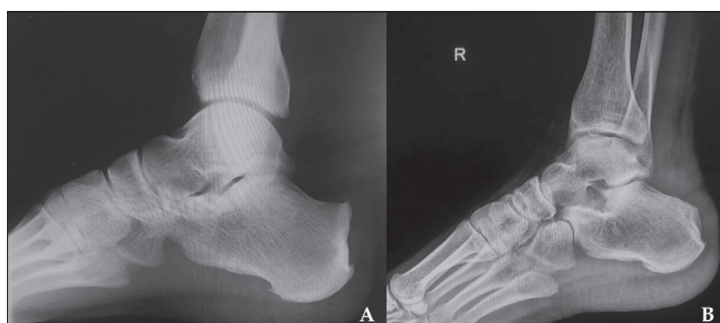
A) Pre-operative lateral radiograph; B) postoperative lateral radiograph
